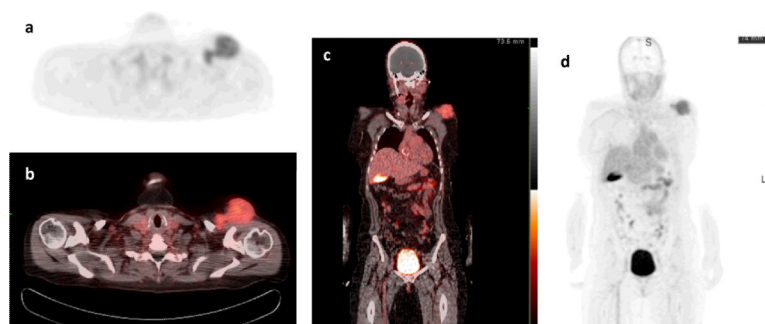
^{18}F -Fluciclatide PET (a,d) and PET/CT (b,c) scan of a patient with metastatic melanoma using (axial (a,b) and coronal (c,d)). Note the specific localization of tracer uptake to the left shoulder. The remaining tracer distribution is physiologic.
